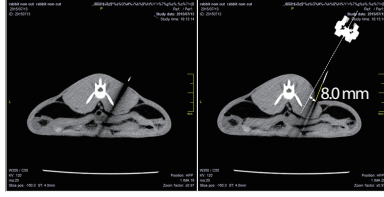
CT Image of Deflected Needle
